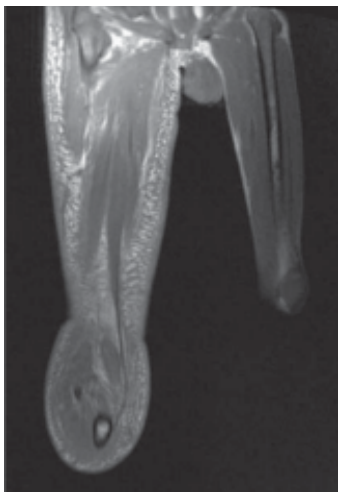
T1 weighted spin echo coronal MR image shows hypertrophic muscles and subcutaneous tissues of the right thigh.
